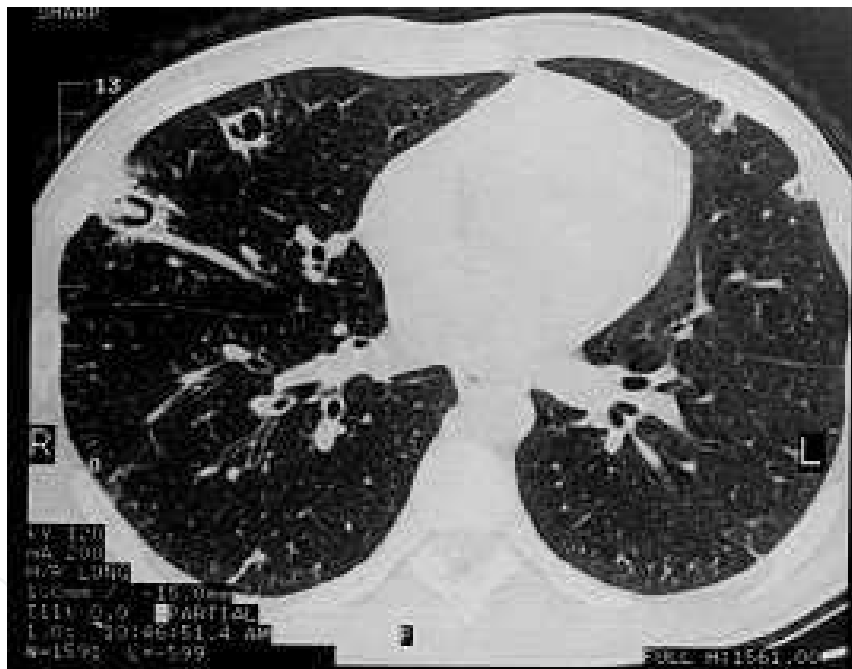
Computed tomography scan showing peripheral cavitary nodules with thick irregular walls from 1 to 3 cm of size
